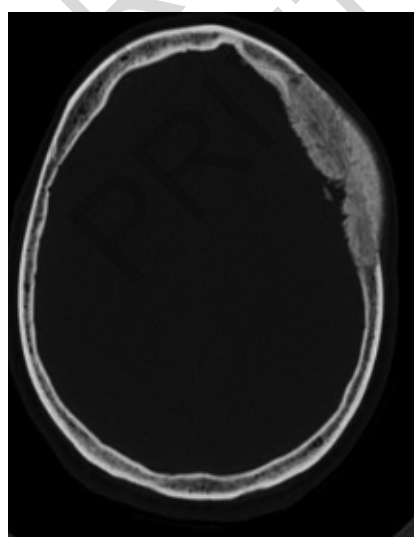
Preoperative axial bone CT scanMa.
